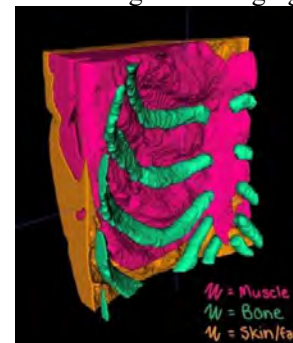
3D cad model of MRI scan and image processing of a right chest area
